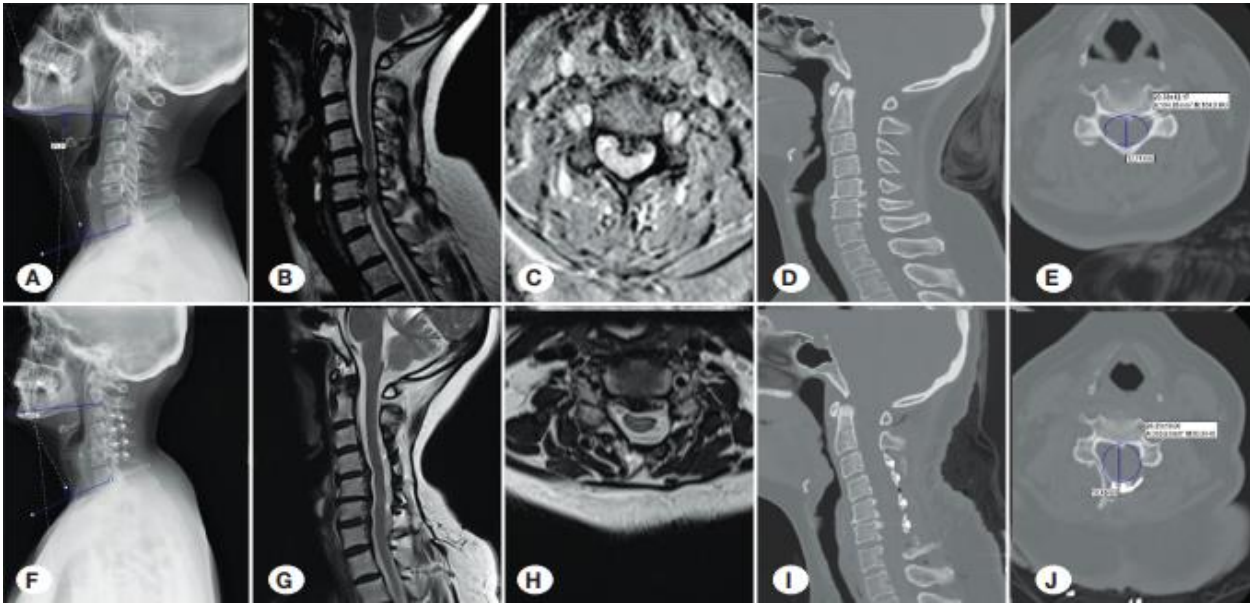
(A) Preoperative radiograph of lateral cervical presenting C2-C7 Cobb angle; (B) Axial; (C) MRI presenting compression of the spinal cord; (D) Axial; (E) CT scan presenting compression of the spinal cord; (F) Cobb angle (C2-C7) postoperative; (G) Axial; (H) MRI scans post-LP; (I) Axial and (J) postoperative sagittal
